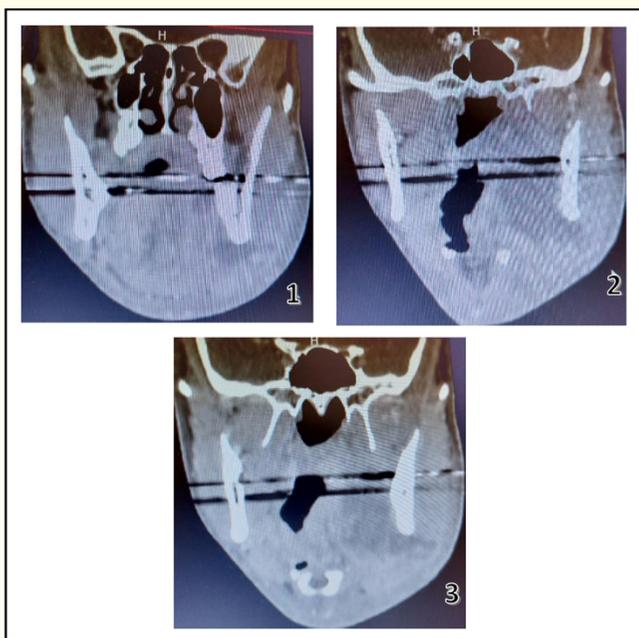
Three coronal CT images, showing radiolucent area in relation to the left mandibular area, causing displacement of surrounding soft tissue and airway narrowing.
